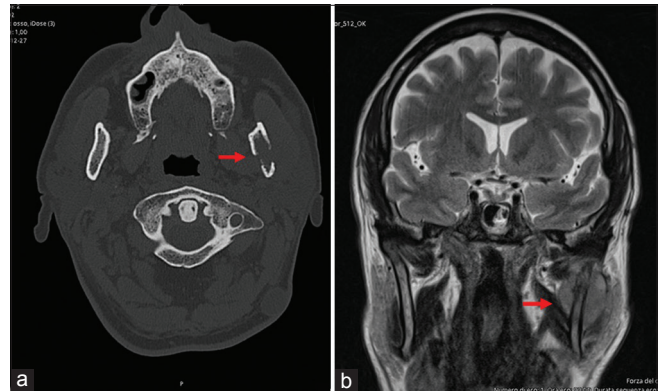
Computed tomography and magnetic resonance imaging: axial view and coronal view (a and b); the red arrow indicates the mandibular tumour
